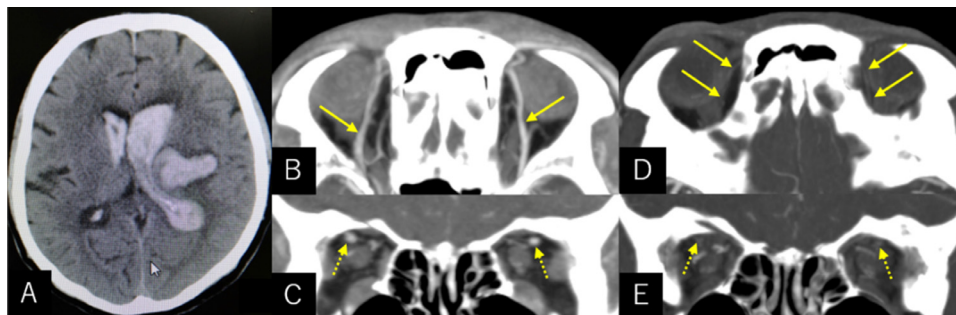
Axial computed tomography (CT) scan of a 53-year-old man at showing a left thalamic hemorrhage accompanied by massive intraventricular hemorrhage (A). Postcontrast axial (B, D) and coronal (C, E) CT images at presentation (B, C) and on POD 7 (D, E), respectively, showing a remarkable reduction in the diameters of both superior ophthalmic veins on the axial (B and D, arrow) and coronal (C and E, dashed arrow) images.
